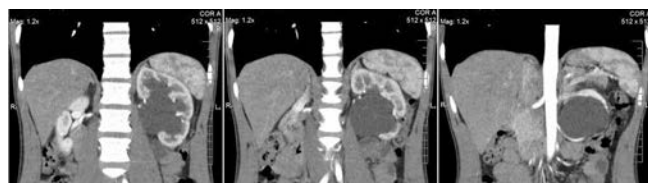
Left crossing vessel detected in CT examination
